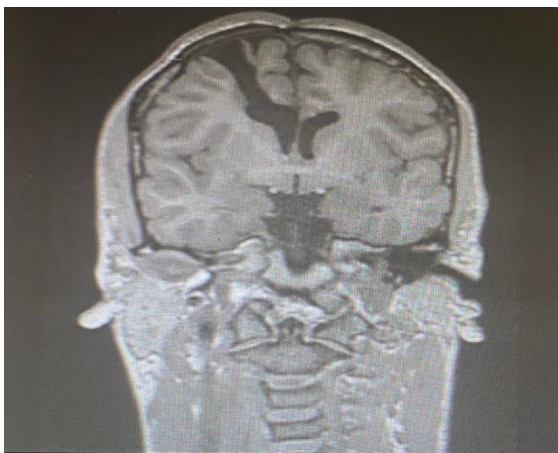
Post MRI report of patient underwent intracranial surgery.
